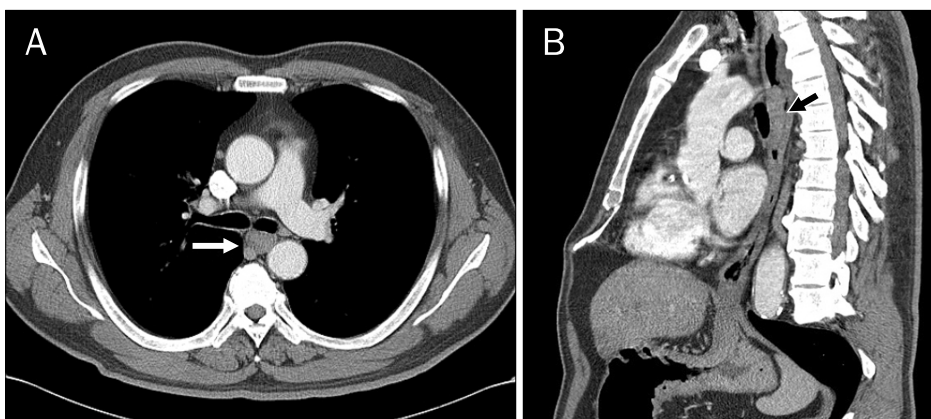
Chest computed tomography findings. (A) There is a mediastinal solid mass arising from the esophagus wall (arrow). Its density is homogenous. (B) Sagittal reconstruction view shows a well-circumscribed longitudinal mass, following the path of the esophagus (arrow). There is a posterior displacement of the esophageal lumen by the mass.
